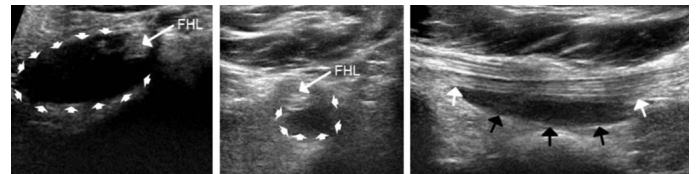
(left) Massive hypoechoic area (small white arrows) around the FHL on ultrasound sagittal view (central) Moderate amount of hypoechoic area (small white arrows) around the FHL on ultrasound sagittal view (right) Moderate amount of hypoechoic area (small black arrows) around the FHL (small white arrows) on an ultrasound coronal view.
